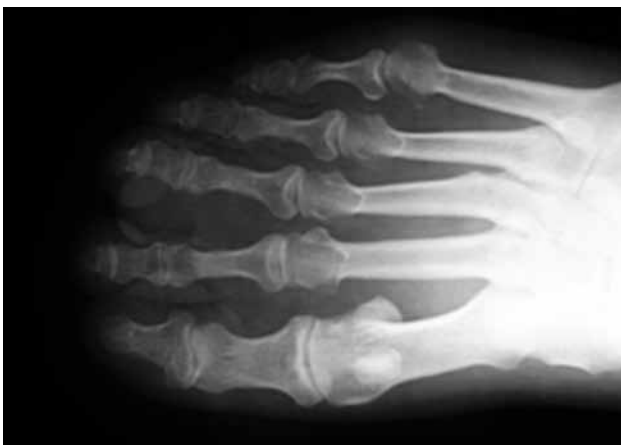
Radiography showing the soft tissue shadow, no bony involvement.
